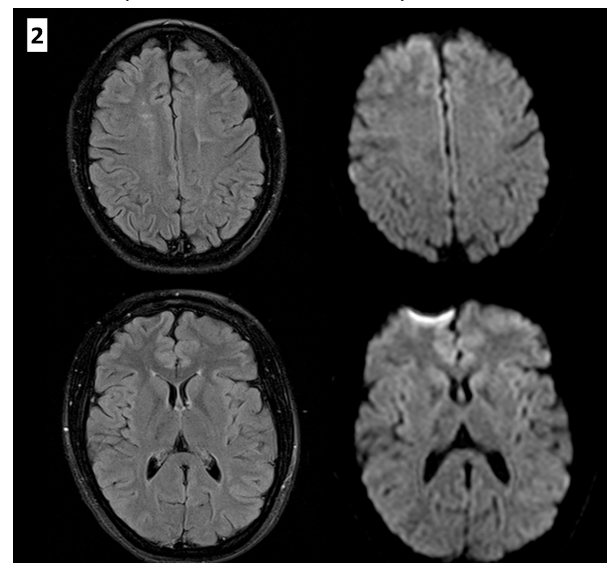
MRI follow-up at six months showing a major radiological improvement in FLAIR and DWI sequences.
